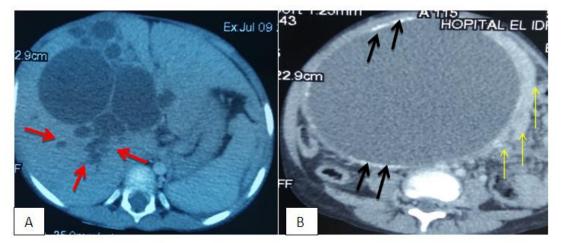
axial CT - Kystic mass of the hiliary plaque with well-defined limits. <u>A</u>: detection of dilatation of bile ducts intra hepatica (red arrow) and, B: the presence of calcifications in the walls (black arrow). It also has a masse effect on pancreas (yellow arrow) and abdominal vessels which are however permeable.
